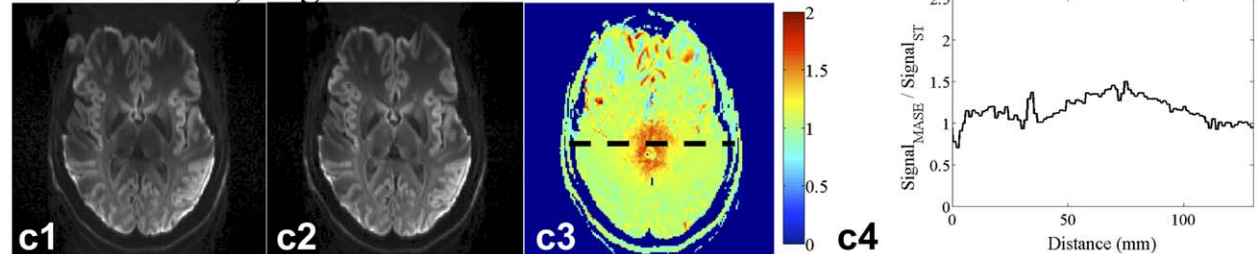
Single-refocused (A) and twice refocused (B) 7T brain DWI acquired in a healthy subject, using 20 diffusion directions. C: DWI acquired in another healthy volunteer using 68 diffusion directions. A1,A2,B1,B2: Trace-weighted signal intensity of 20-directions ST, MASE, TRSE, and TRASE. C1,C2: Trace-weighted signal intensity of 68-directions ST and MASE. A3,B3,C3: Signal intensity ratio between adiabatic and conventional acquisitions; A4,B4,C4: Profiles along a horizontal line for images A3, B3 and C3 respectively. When using adiabatic refocusing pulses, the increase in signal intensity at the center of the field of view was up to 64% for MASE versus ST (20 directions), 140% for TRASE versus TRSE (20 directions) and 50% for MASE versus ST (68 directions).
